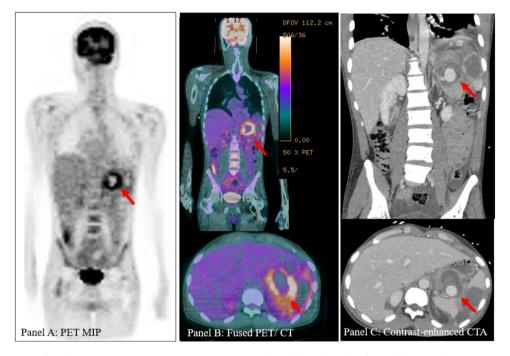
¹⁸F-FDG PET/CT images of a splenic artery mycotic aneurysm. PET MIP (A) and axial/coronal PET/CT fusion (B) images demonstrate an intensely peripherally hypermetabolic lesion with central photopenia within the left upper abdomen, adjacent to the spleen. This was favored to be an abscess but difficult to characterize on low-dose CT without IV contrast. Axial/coronal contrast-enhanced CTA (C) images demonstrate a fluid collection between the stomach and spleen with internal enhancement that communicated with the splenic artery. This was new compared to a CT from one month earlier.
